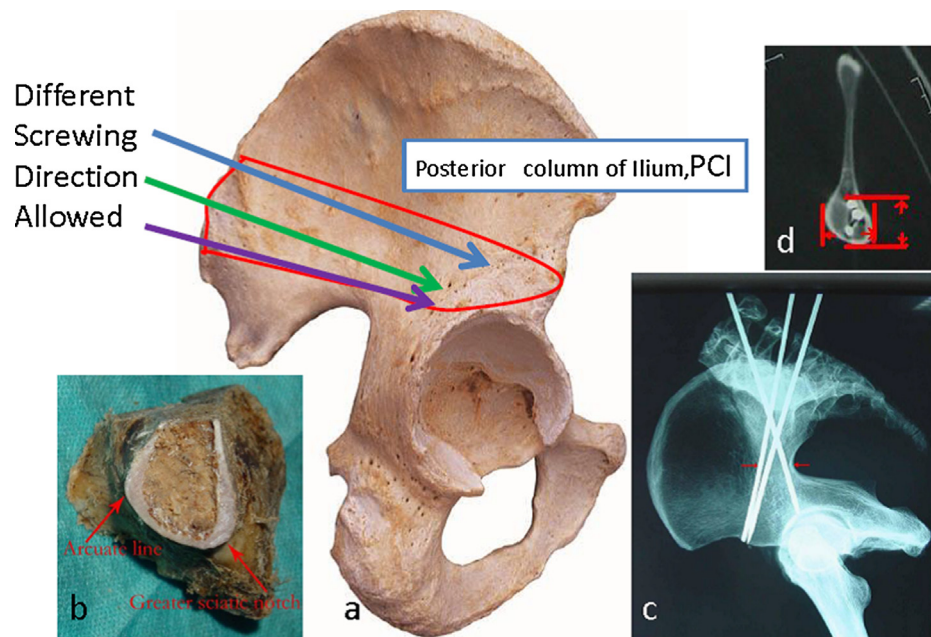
The different visual angle of iliac bone: (a) the red line represents the safe area of PCI for iliac screw fixation, the blue, green and purple arrow represent different screwing direction allowed; (b): the coronal profile of PCI perpendicular to great sciatic notch; (c) and (d): the orientation and position of Kirschner wire in PCI by X-ray and CT.
